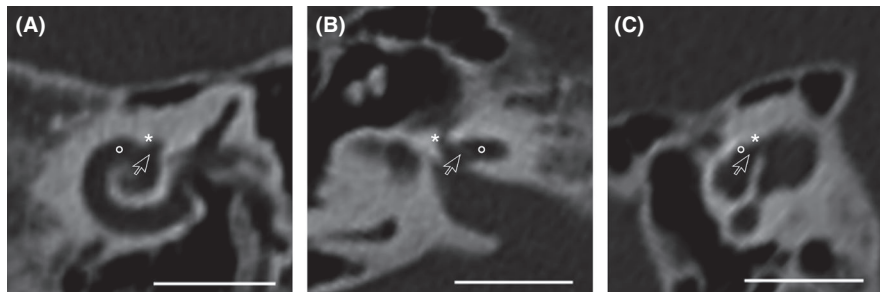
Cochlea-facial nerve dehiscence on preoperative CT images by means of open-source software Osirix MD (Pixmeo, Los Angeles, California) using three-dimensional multiplanar reconstruction. The main plane (A) is adjusted parasagittal through the basal turn of the cochlea (*dot*). Its crossing point with the other two orthogonal planes (B, axial, and C, mid-modiolar) is the dehiscence (*arrow*). *Asterisk*: labyrinthine segment of the facial nerve. Left ear; 1 mm slice thickness; Scale bar: 1 cm
